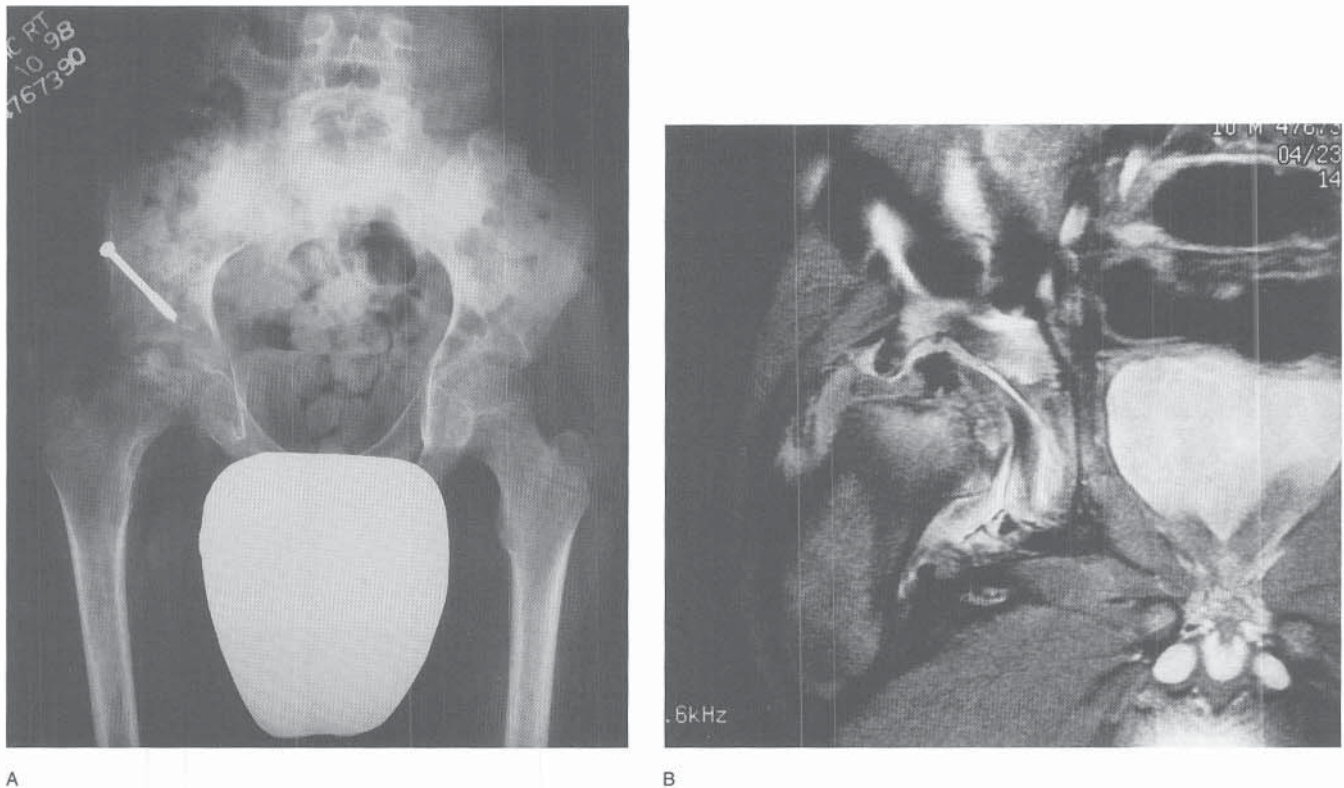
A case of postoperative hinge abduction in a 10-year-old boy 9 months after a Salter osteotomy, resulting in severe limitation of abduction. A, AP radiograph showing healed osteotomy and apparent loss of joint space, with lateralization of the femoral head. B, MR image showing indentation of the lateral acetabular lip into a depression in the femoral head. A medial joint space is evident in this imaging study.
